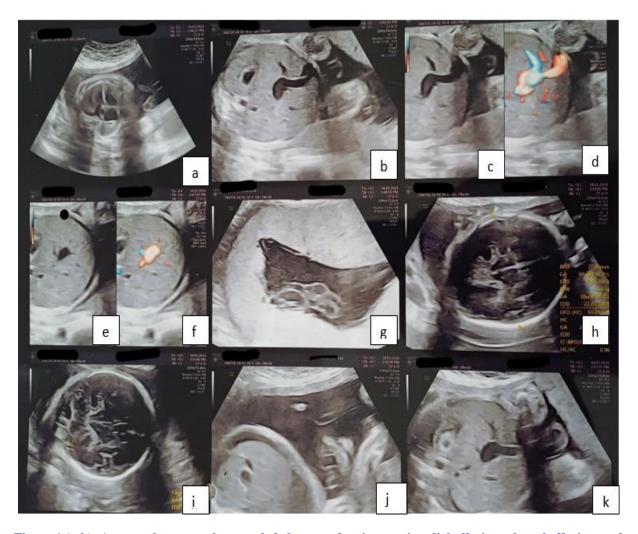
(a-k): Antenatal sonography revealed changes of ascites, pericardial effusion, pleural effusion, and placentomegaly consistent with hydrops fetalis.
